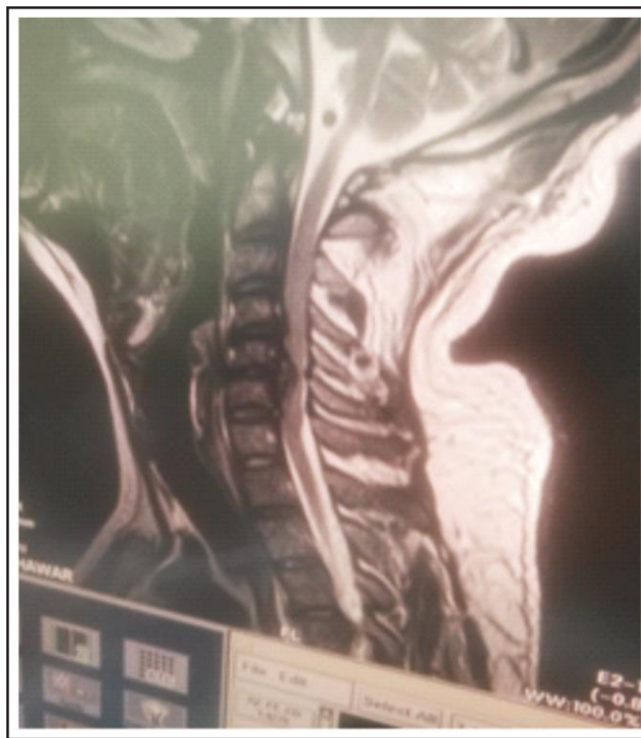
MRI Cervical Spine showing disc prolapse at C5-C6
